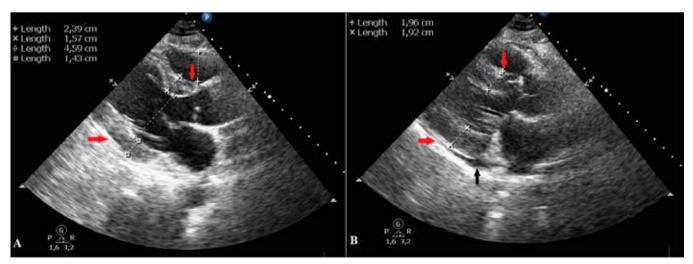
Echocardiography performed on admission: Parasternal long axis (PLAX) view in diastole (A) and systole (B) shows significantly thickened left ventricle posterior wall and septum (red arrows) and minor pericardial effusion (black arrow)
